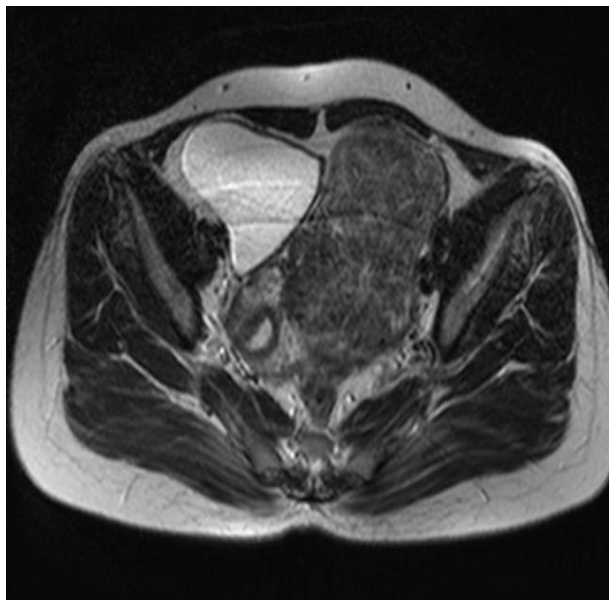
MRI axial T2 W images of Broad ligament fibroid. A large well defined mass lesion is seen in the left adnexal region closely abutting the left lateral wall of uterus and displacing the uterus towards the right side.
